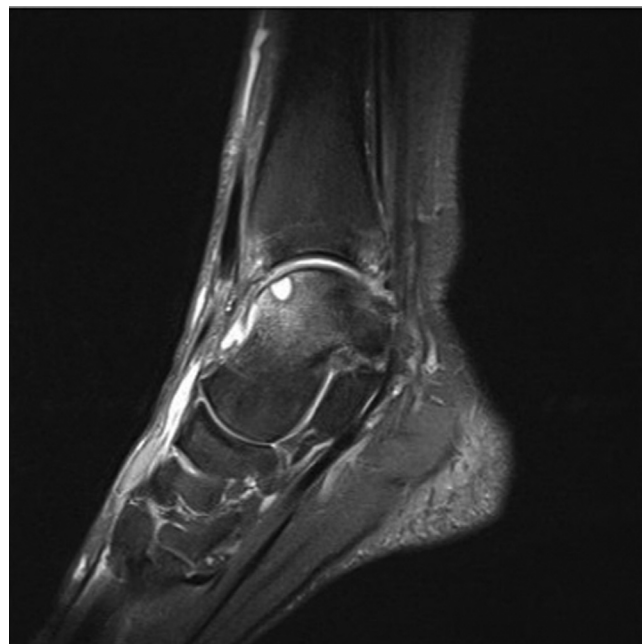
Preoperative magnetic resonance image, sagittal view, of medial osteochondral lesion.
